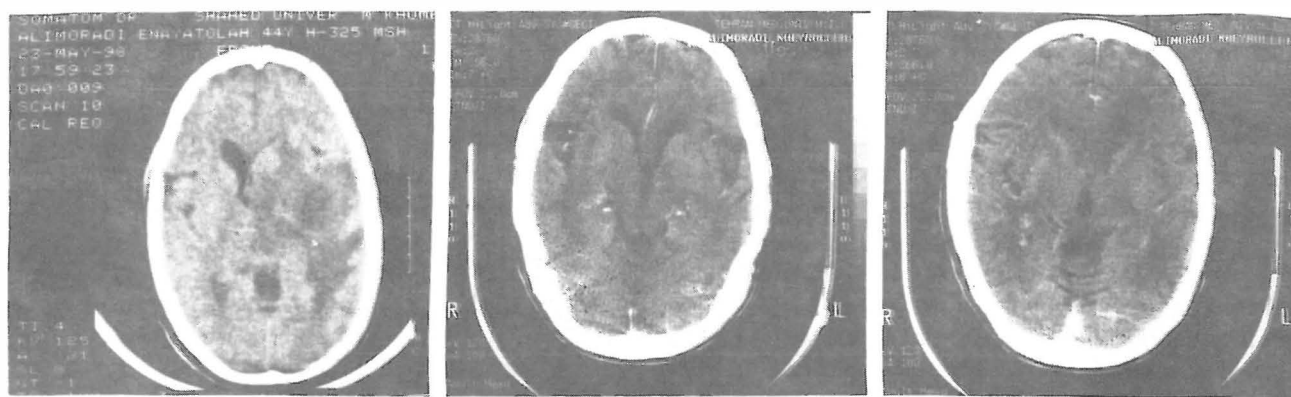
Preoperative CT scan of case II depicted a left temporal lobe lesion with perifocal edema and minimal enhancement (A). Postoperative computed tomography at one week (B) and 5 months (C).
